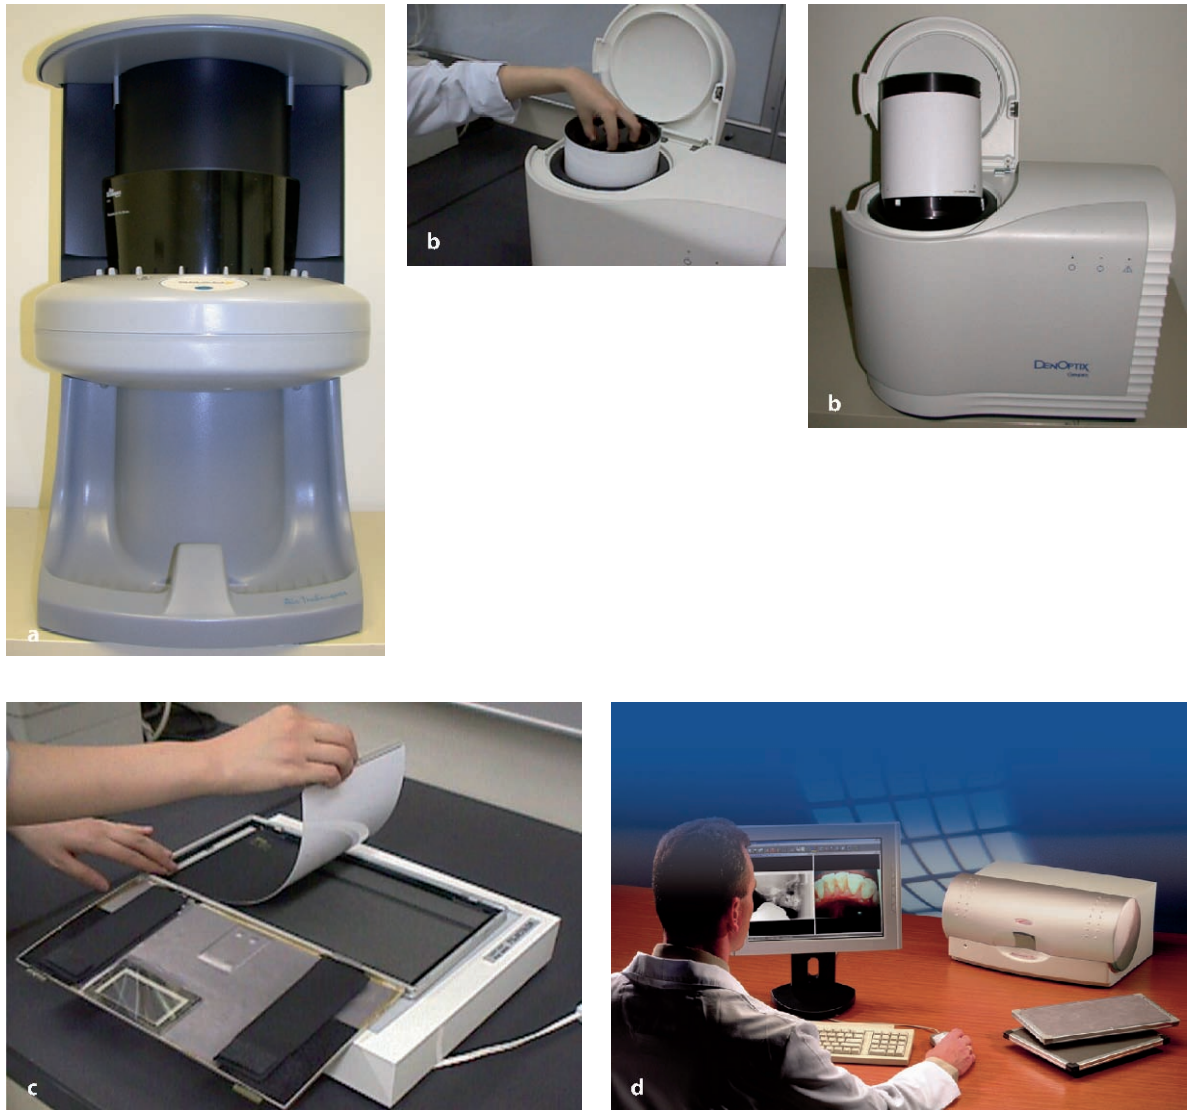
a Air Techniques (NY) ScanX photostimulable phosphor plate laser scanner. b DenOptix (Danaher/Gendex, Des Plaines, IL) laser scanner with a photostimulable phosphor plate attached to drum ready for processing together during the scan. c Loading a photostimulable phosphor plate into a soft cassette. d Kodak/Orex Paxorama works with existing X-ray generator and photostimulable phosphor plate
